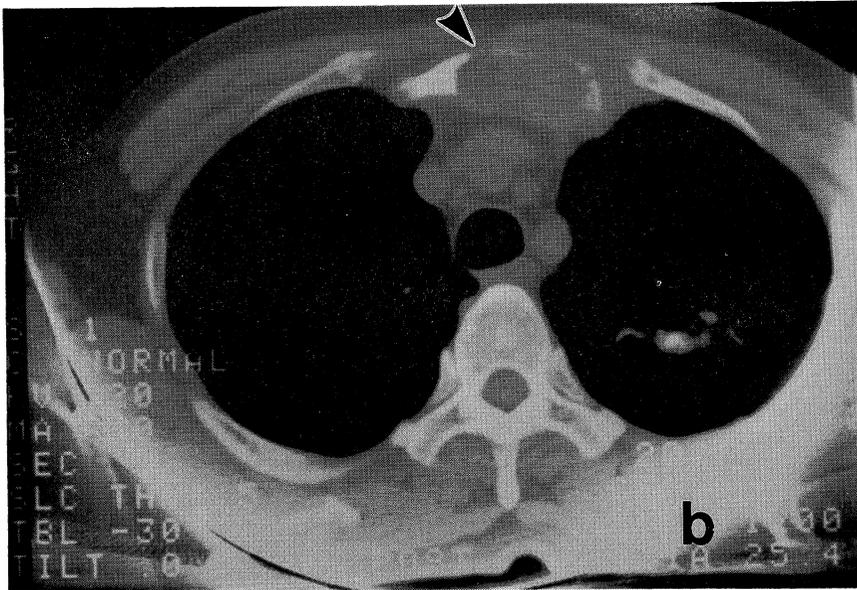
Computed tomography demonstrated the encroachment of the sternum by tumor.
